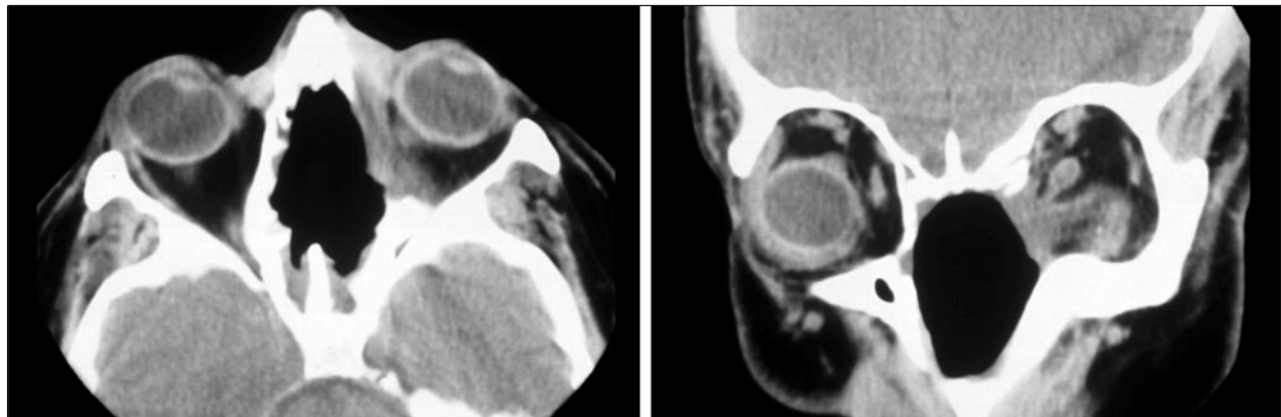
Case 1. Axial (left) and coronal (right) computed tomographic scans show extensive destruction of septum, ethmoid, and antral bony structures. The left medial orbital wall is absent and a soft tissue mass envelops the medial rectus muscle.
